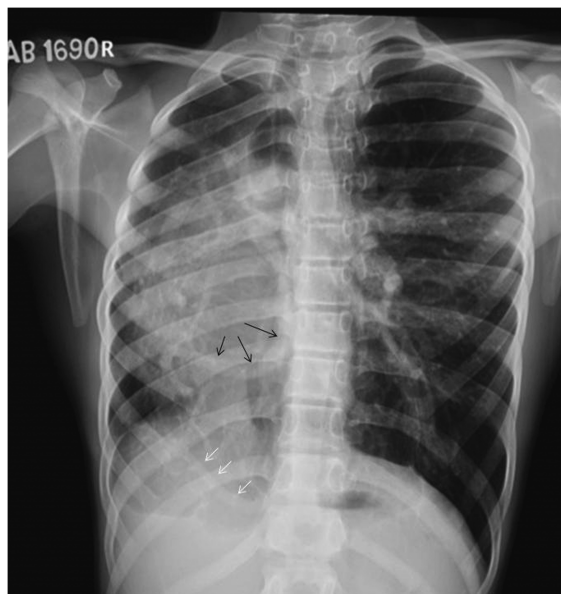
Chest Radiograph showing loss of volume in the right lung with shift of mediastinum to the right. Two abnormal vessels are seen one coming from right upper lobe and descending down (black arrows) and another vessel coming from below right diaphragm and ascending towards lower lateral part of the right lung (white arrows).
